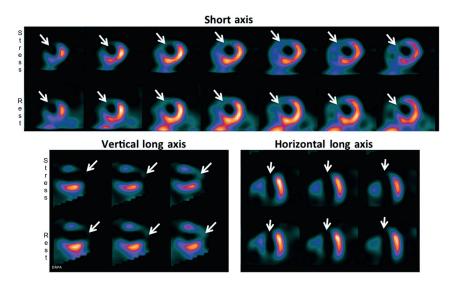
Regadenoson stress and rest SPECT images of an 83-year-old male with prior anterior wall myocardial infarction 20 years ago. Coronary angiography revealed completely occluded LAD proximally, which could not be revascularized. The RCA and LCX showed 50–60% narrowing, which was not revascularized. He has been complaining of mild exertional shortness of breath and chest heaviness over the last few weeks. There was no chest pain or ST segment depression with regadenoson. There is a large dense scar involving the anterior wall, septum, and apex. There is no ischemia. The apex was dyskinetic and the anterior wall and septum were akinetic and the global LVEF was severely impaired at 37%.
